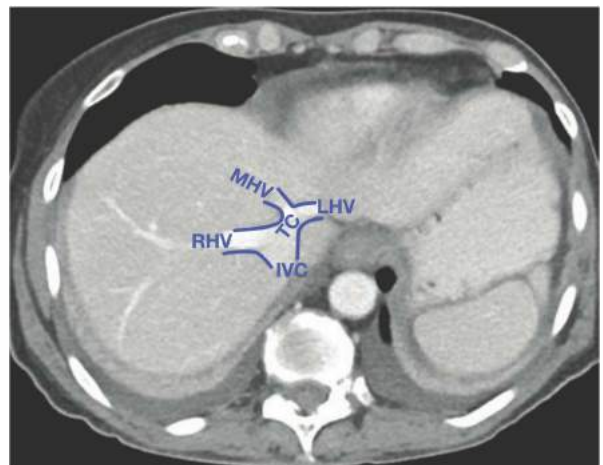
• Axial CT scan showing the relationship of the hepatic veins as they converge to the IVC. The middle (MHV) and left (LHV) hepatic veins join to form the truncus communis (TC), which empties into the IVC. The right hepatic vein (RHV) is also shown, similarly draining into the IVC.
